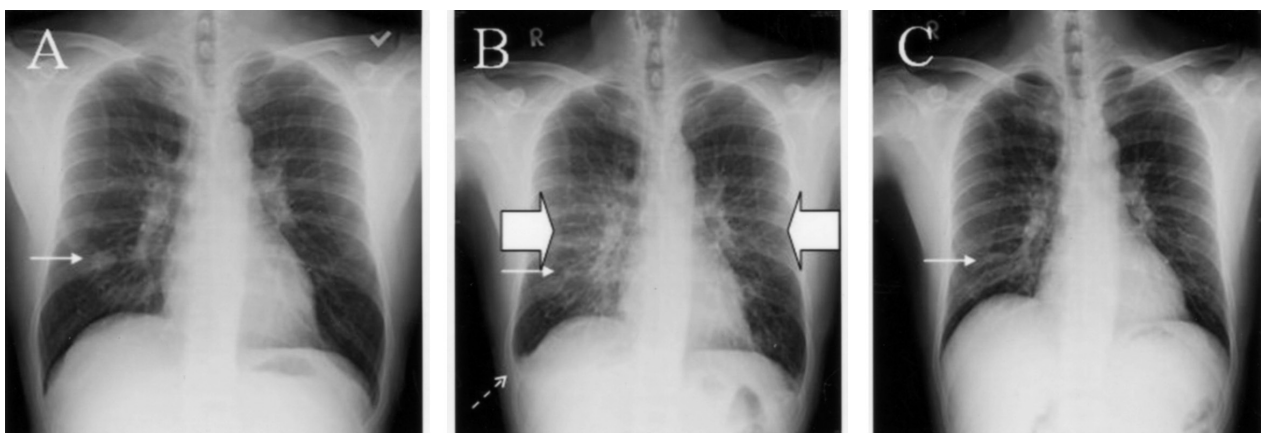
(A) The initial diagnosis of lung cancer. CXR showed a soft tissue nodule about 2.3 cm in size in the right lower lung field (white arrow). (B) After 43 days of TKI treatment, the chest plain film showed diffused central peribronchovascular bundle thickness (large white arrows) in both hilum regions, more on the right side, and a new onset of right pleural effusion (white dashed arrow). (C) After 9 days of steroid treatment.
